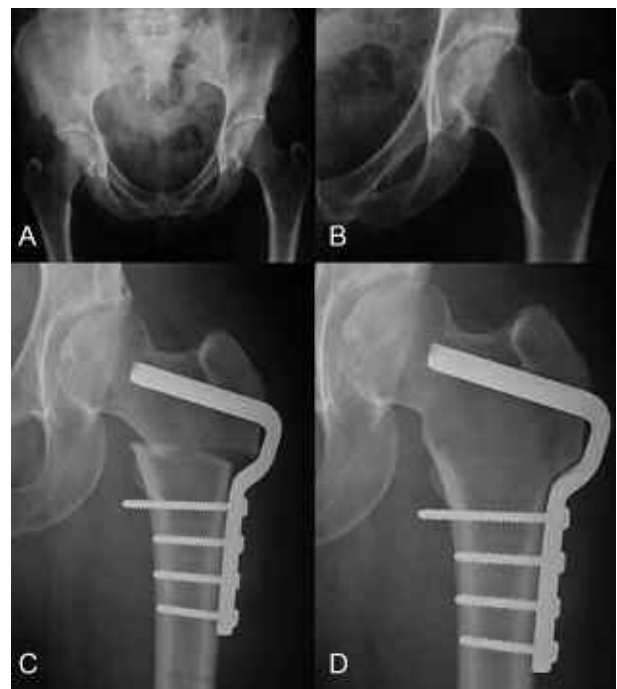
Bilateral coxa vara. A, B) preoperative X-ray of the pelvis and of the left hip. C) postoperative X-ray after varus femoral osteotomy of the left hip. D) consolidation of the osteotomy
